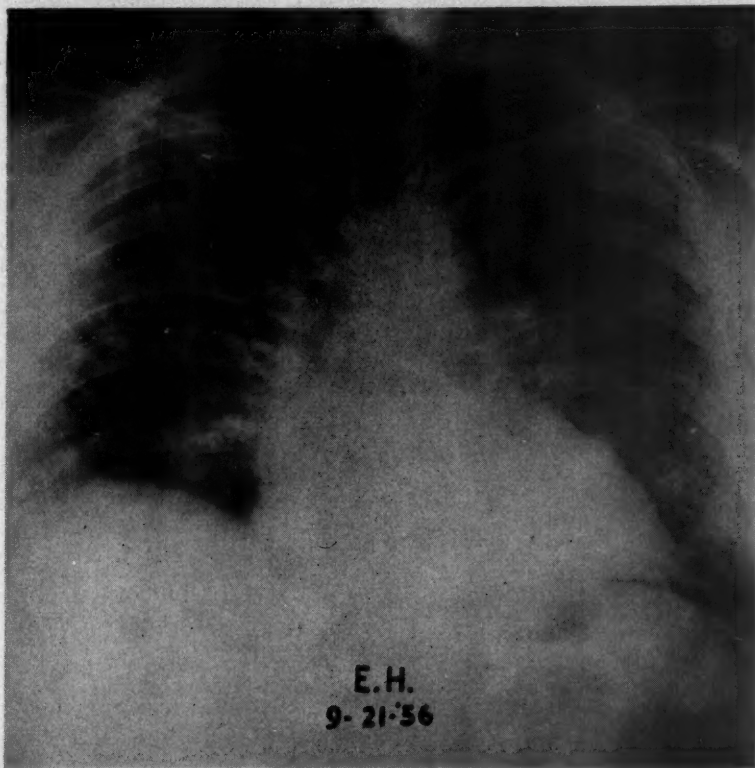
Chest x-ray of case 1 during acute illness, showing nodular densities in both lung fields and enlargement of hilar lymph nodes.
